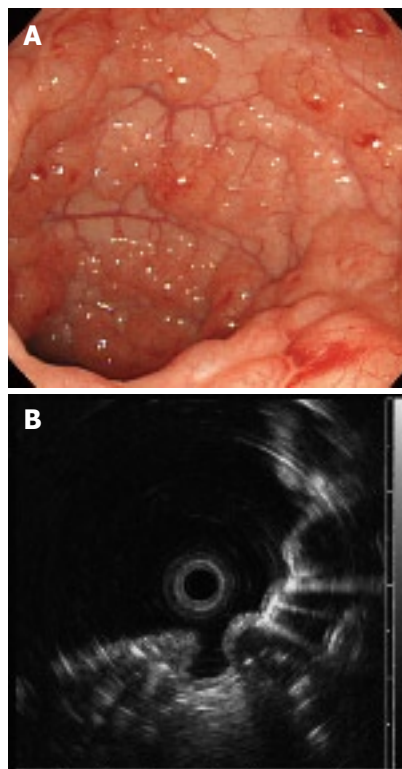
Colonoscopy on admission showing multiple round and smooth-surfaced elevated lesions in the sigmoid colon (A) and endoscopic ultrasonography (EUS) revealing hyperechoic lesions and acoustic shadows in the submucosal layer (B).
